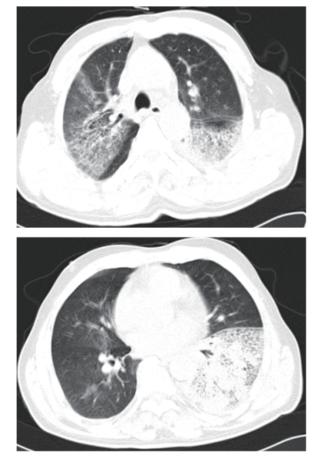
Chest CT of a 65-year-old male patient on April 6th, 2013.
